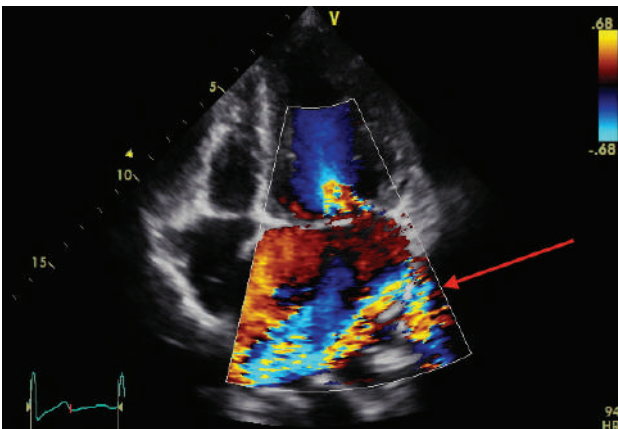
Rheumatic mitral valve; severe eccentric mitral regurgitation demonstrated with colour Doppler. The regurgitation follows the posterior wall and fills multiple pulmonary veins (red arrow)
